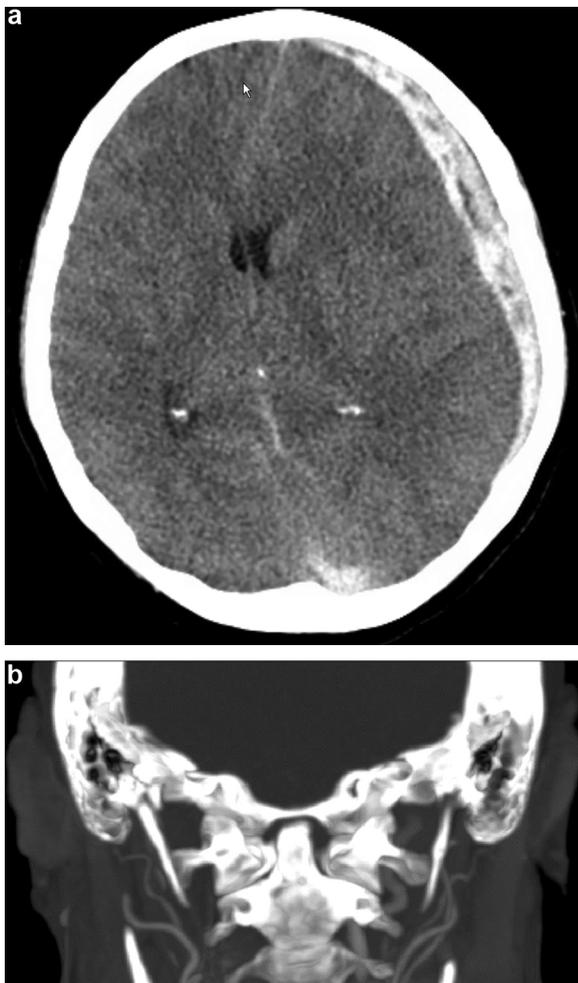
57-year-old female with brain death. Initially presented with headaches and subsequently became unresponsive. (a) Axial noncontrast CT demonstrates subdural hematoma with midline shift.
